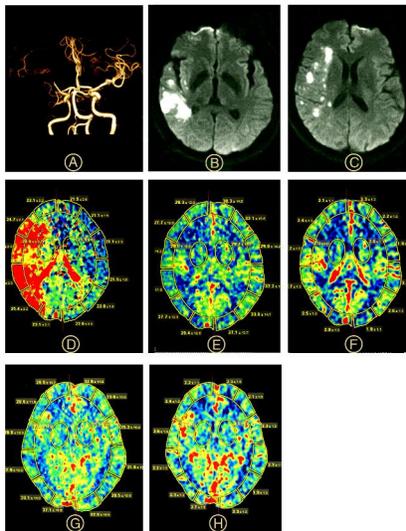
Case 1, male, aged 53, Slurred speech, paralysis of the right limbs for 14 hours (A)M1 segment of the right middle cerebral artery was occluding. (B and C)DWI showed a right temporal lobe infarction. CTP showed TTP(D) was obviously abnormal. After treatment, rCBF(G) and rCBV(H) were improved than rCBF(E) and rCBV(F) before treatment.
